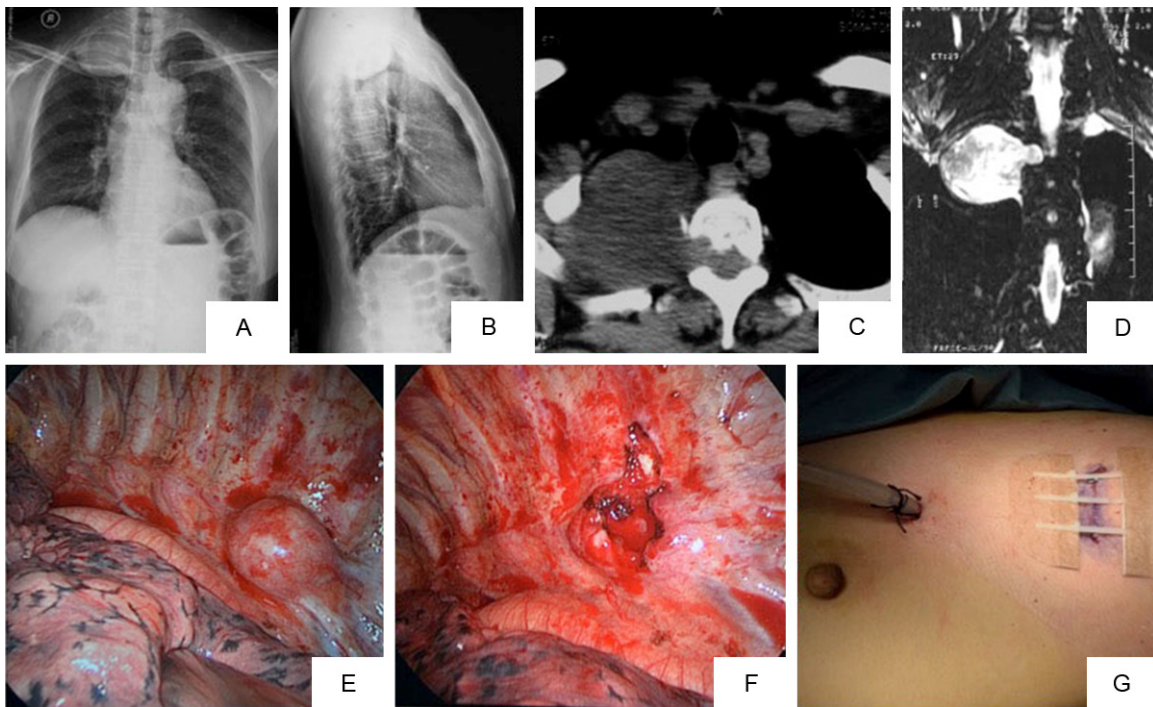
A 47-year-old woman with a neurogenic thoracic paravertebral tumor located at T2. A, B. Anteroposterior (AP) X-ray and lateral plain radiographs, showing a circle-shaped shadow in the right upper thoracic region. C, D. Computed tomography scan and T2-weighted coronal magnetic resonance images, demonstrating a tumor mass with a high-intensity shadow located at the posterior mediastinum and extending into the T2-3 intervertebral foramina. E-G. Tumor was removed completely using a thoracoscopy-assisted mini-open approach. A chest tube was placed and removed 3 to 5 days after surgery.
